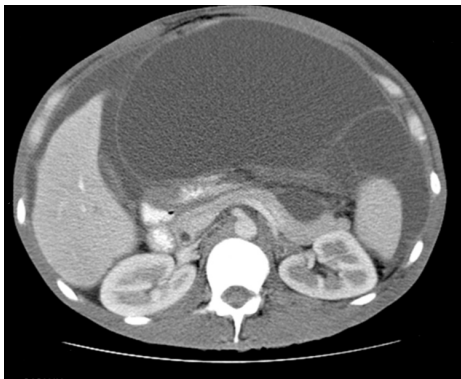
Mucinous ascites on computed tomography^[24]. This computed tomography scan demonstrates mucinous ascites. We also see characteristic findings of pseudomyxoma peritonei: Scalloping of the liver and spleen.
